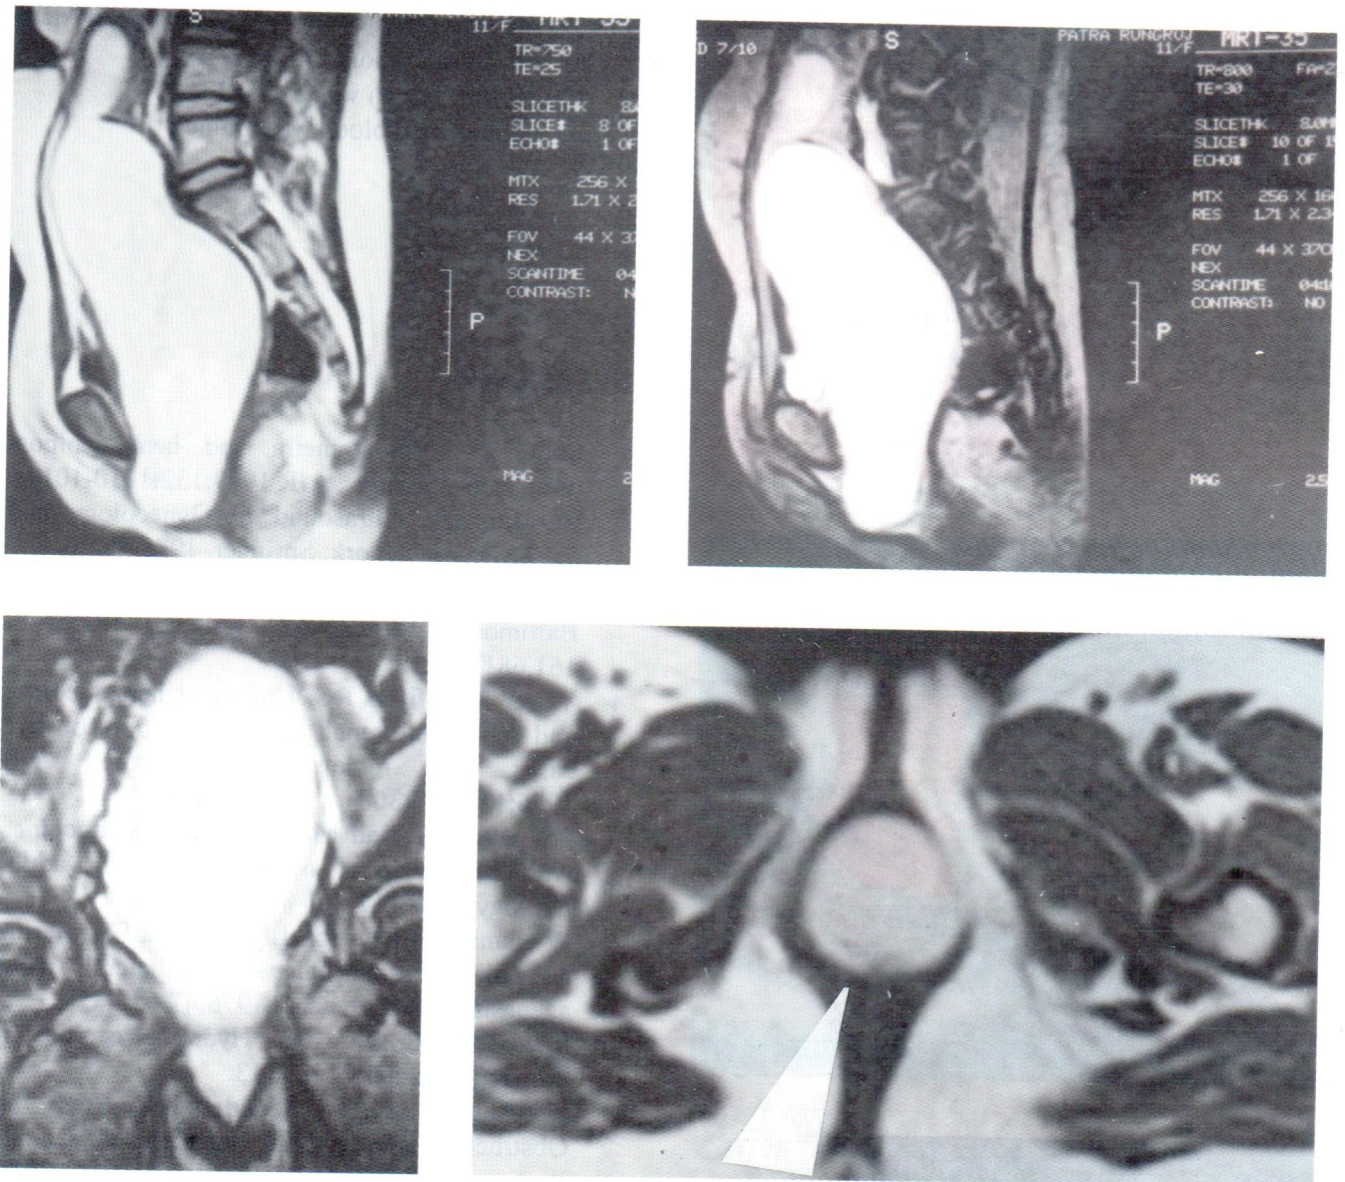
MR images of the distended uterine and vaginal cavity with subacute blood in sagittal and axial T1W and in coronal T2W. The fluid is bright on T2WI and brighter on T1WI and is homogeneous in signal. The arrow shows the imperforate hymen.
